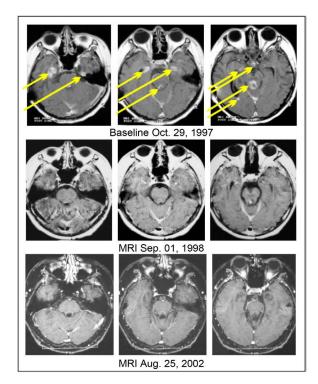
Pilocytic astrocytoma, disseminated to the brain and spinal cord in a 16-year-old male, post-excisional biopsy of the tumor, but without radiation therapy and chemotherapy. Treated with intravenous antineoplastons A10 and AS2-1 under Special Exception from November 5, 1987 until April 7, 2003. MRI of the head, T1-post-contrast. Baseline versus follow-ups showing complete response. Overall Survival from treatment start was over 18 years. The yellow arrows indicate contrast-enhancing lesions.
